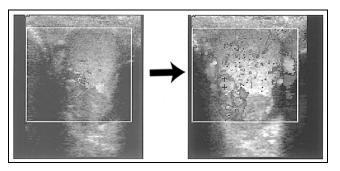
Ultrasound images depicting a varicocele with color flow Doppler sonography used to show an alteration of flow in the dilated vessels (blue \rightarrow red).
